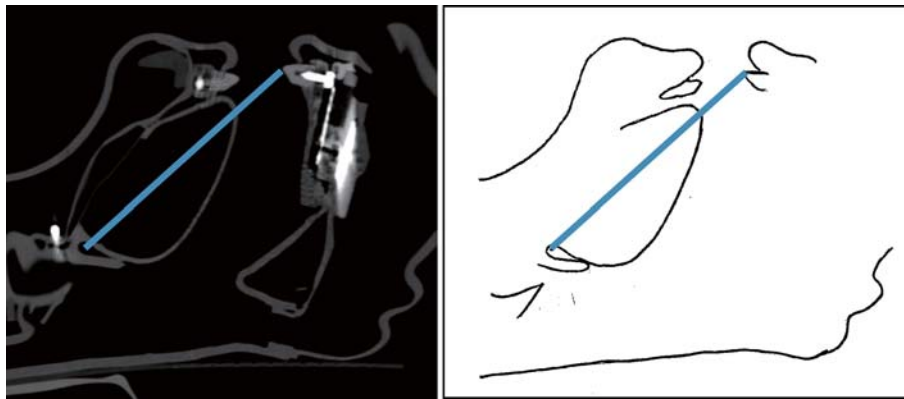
CT scan at rest. Distance from tip of the incisor to the epiglottal area is 9.0 cm.
